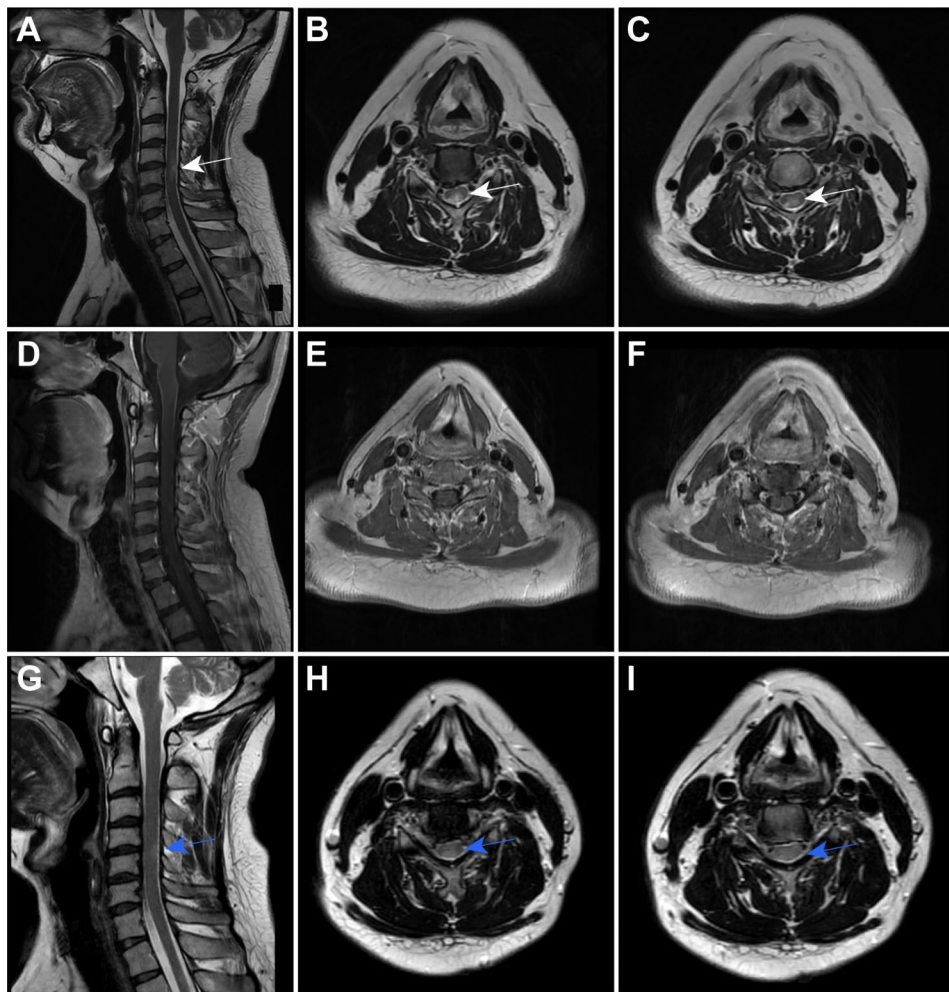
Cervical spinal MRI findings of the patient. The hyperintensity extending along C4-5 in the sagittal T2-weighted image in November 2023 (white arrow, A). The lesion primarily located in the posterior part on axial T2-weighted images (white arrow, B and C). A slight contrast enhancement in the posterior part of the lesion in sagittal (D) and axial (E and F) views of spinal MRI with gadolinium enhancement in November 2023. After 5-month antifungal therapy, near-resolution of the lesion on the cervical spinal MRI in April 2024 (blue arrow, G, H, and I)
